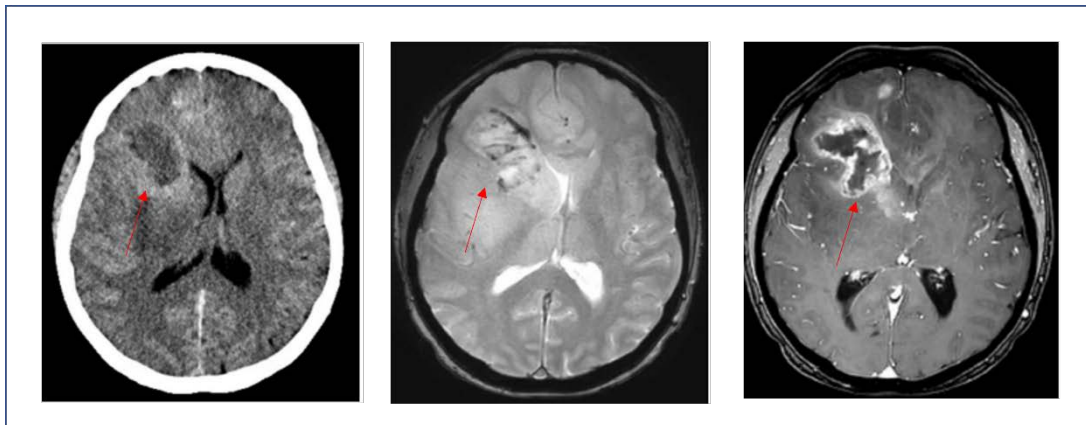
An overview of imaging techniques use to determine the location of abnormal masses within the brain. The mass was identified as a glioblastoma tumour located in the right frontal lobe shown left to right in, an axial CT image, axial FLAIR T2 weighted MRI image and a T1 weighted axial image using gadolinium as a contrast enhance agent. In the T1 contrast enhanced image, additional areas of enhancement lie within the previously described region of ‘FLAIR envelope’. Images extracted from [12]
